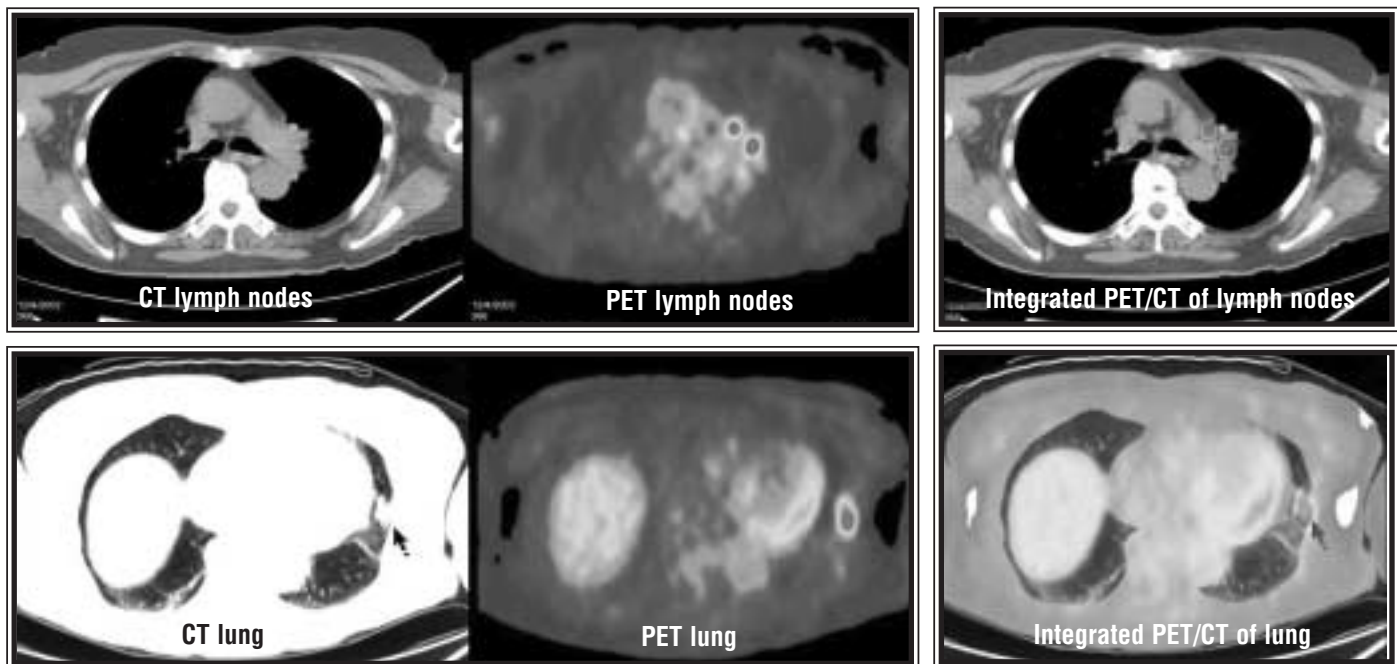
69-year-old woman with a small nodular pleural thickening along the left anterior lateral hemidiaphragm on chest CT. Pathology from VATS revealed moderately differentiated adenocarcinoma and metastatic adenocarcinoma in aortopulmonary lymph node.
